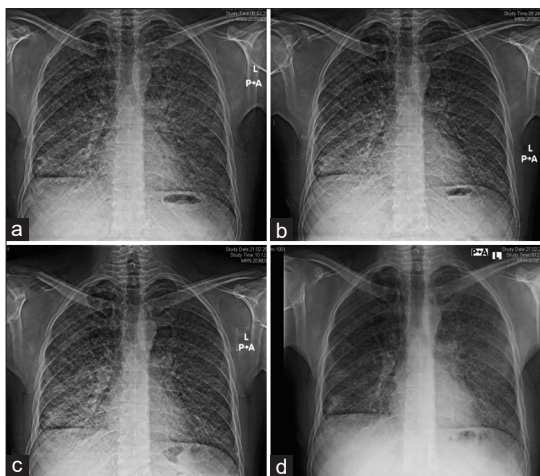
Chest radiograph before (a) and after (b) left lung lavages, and before (c) and after (d) right lung lavages
